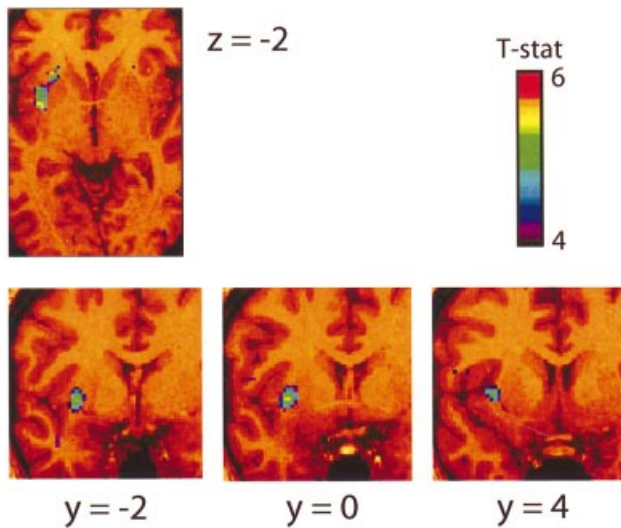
Dopamine release induced by transcranial magnetic stimulation. One axial and three coronal sections of the statistical parametric map of the change in [^{11}C]raclopride binding potential overlaid on the average MRI of all subjects in stereotaxic space. The colour scale represents the t -statistic.
